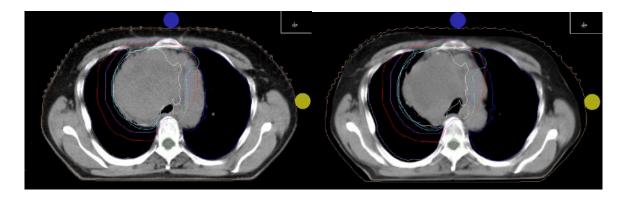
Planning CT images with contoured macroscopic lung cancer and involved lymph nodes as GTV (blue line) and the planning target volume as PTV (red line) before the RT (left picture) and the schrinked tumour volume as GTV1, after 45 Gy irradiation (right picture).
